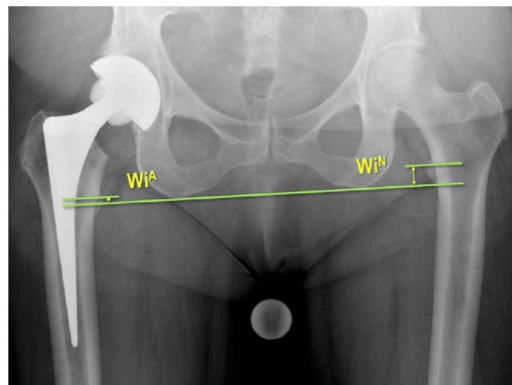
The Williamson et al. method of measuring LLI on a radiograph. The reference line is at the inferior interischial line and two further parallel lines are drawn through the most prominent part of the lesser trochanters. The perpendicular distance between is measured and compared. In this case the distance W^A for the arthroplasty is *smaller* than W^N for the native hip, indicating that the operated side has been lengthened.
